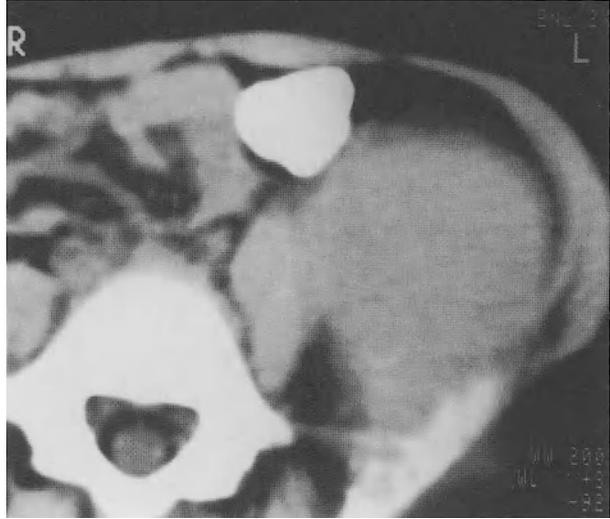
CT scan cut at level of top of iliac crest showing a mass of Ewing's sarcoma
